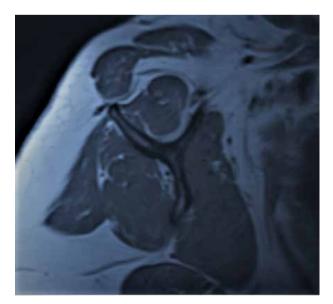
T1 Oblique sagittal section on MRI
